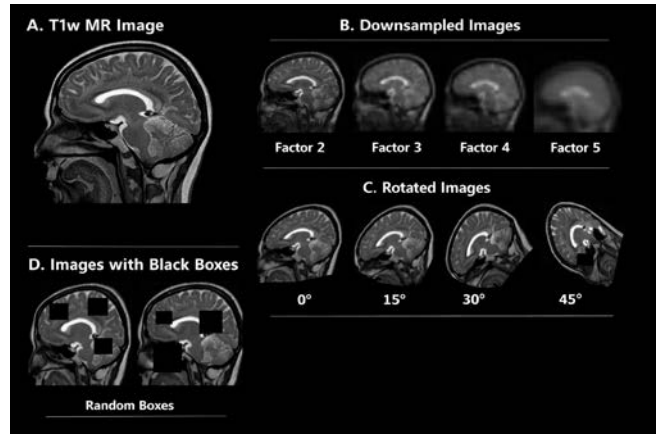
Techniques for data augmentation on MRI scans: (A) Original T1-weighted MRI scan, (B) Down sampled MRI scans by a factor of 2, 3, 4, and 5, (C) Rotation of MRI scans at intervals of 15 degrees, and (D) Black boxes of varying sizes placed to imitate occlusions.
